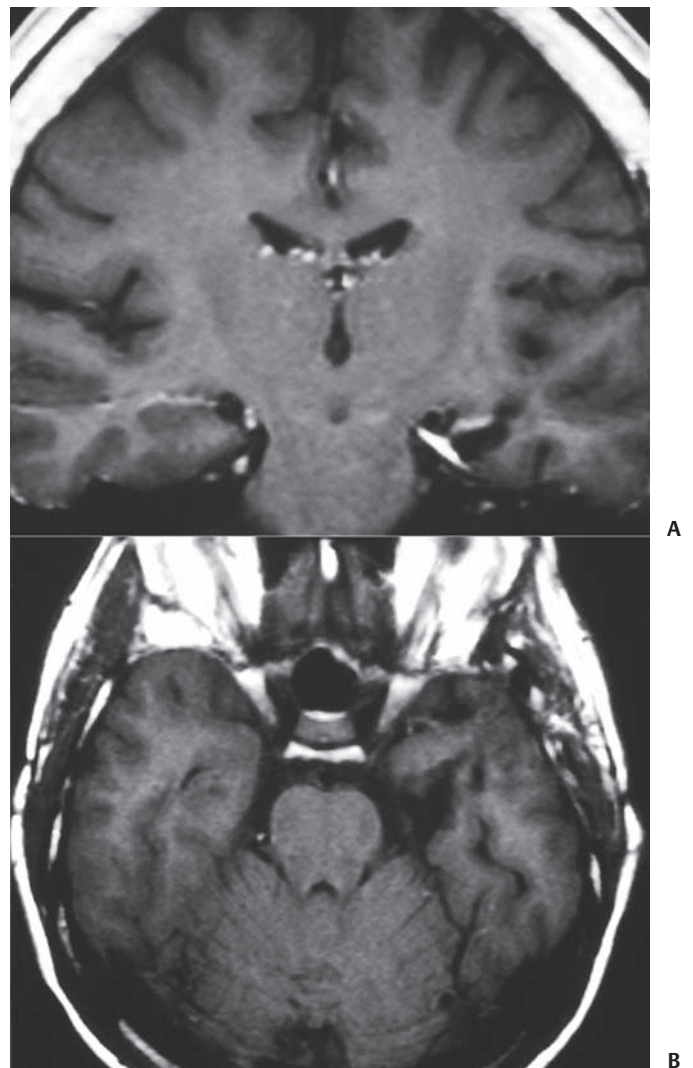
Postoperative magnetic resonance imaging 6 months after selective hippocampectomy. (A) Coronal T1-weighted image along the plane of the transinsular-temporal stem dissection. (B) Axial image showing the resection bed.
